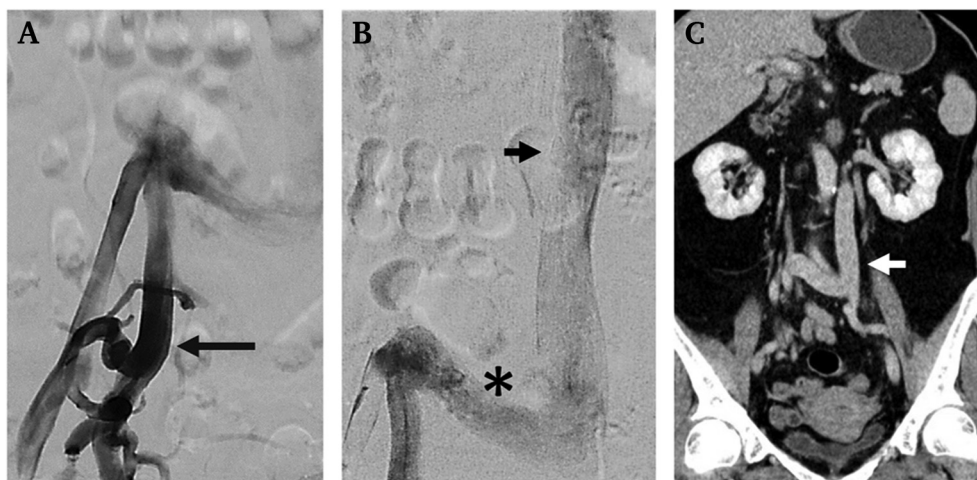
Venogram from the right common femoral vein showing tortuous right femoral vein (long black arrow) (A) and abnormal venous drainage route through intersupracardinal anastomosis (black asterisk) to the left inferior vena cava (IVC) (black short arrow) (B). The CT image demonstrated the venous drainage route of the left IVC (white arrow) (C).
